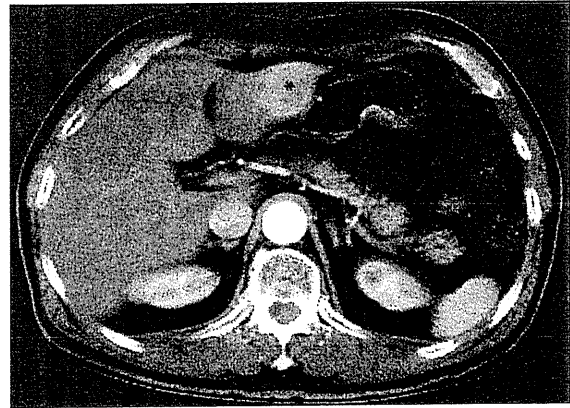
Findings of computed tomography. A hypervascular nodule is seen in the left lobe of the liver (asterisk).
